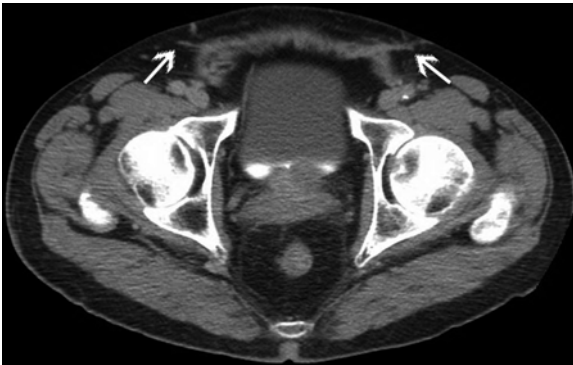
The bilateral flat mesh (*white arrows*) seen in this axial CT of the pelvis look similar to scar tissue, making it difficult to differentiate subtle mesh abnormalities.
